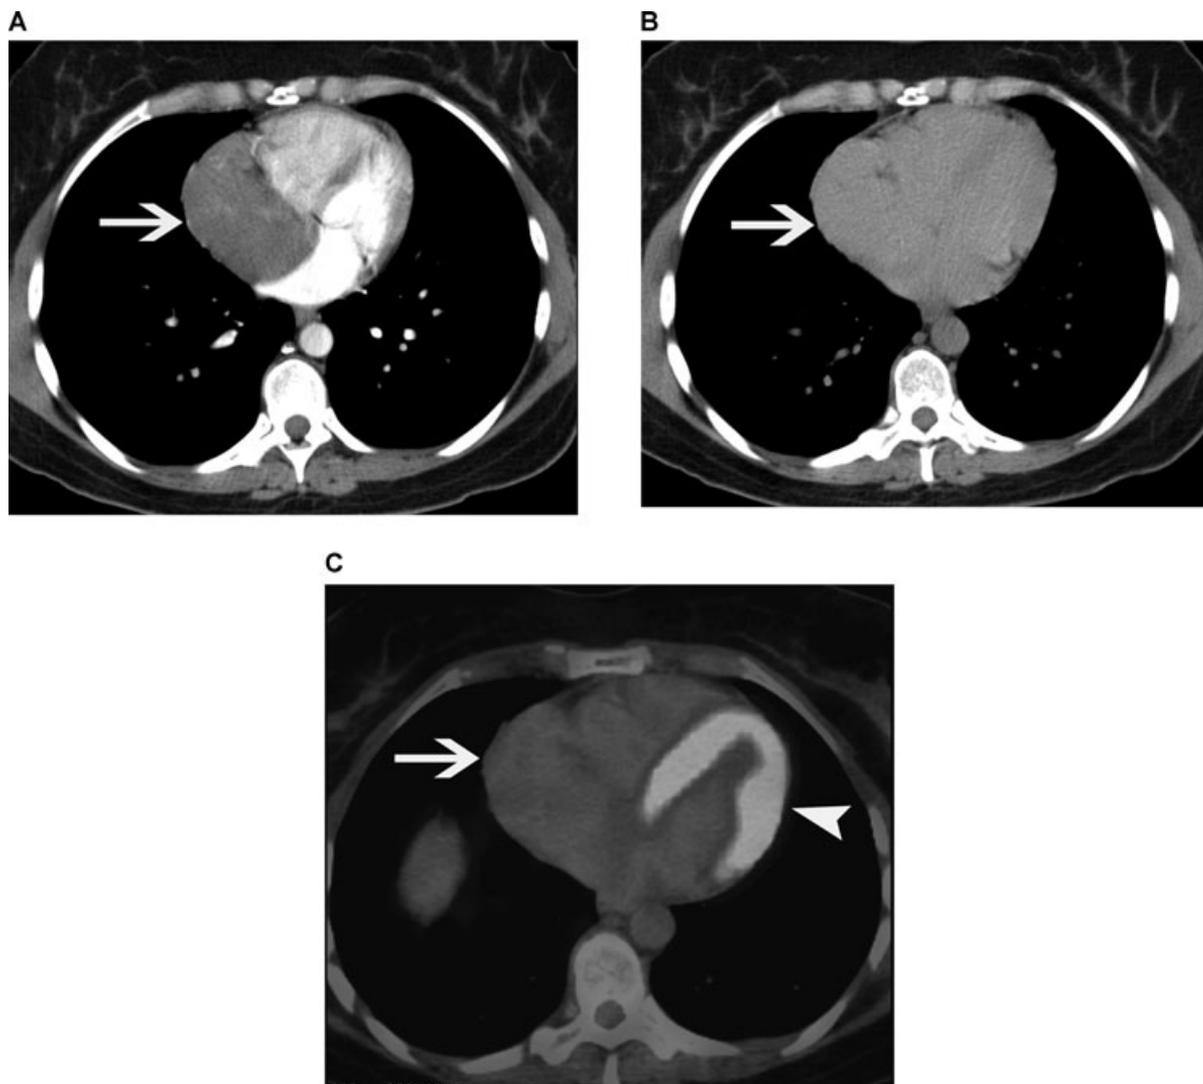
Computed tomography (CT) and FDG PET/CT images. A. CT image obtained immediately after administration of intravenous contrast shows large right atrial mass (arrow). B. Delayed CT image obtained about 5 minutes later shows that the tumor (arrow) has enhanced to the same degree as the blood pool indicating that it is highly vascular. This pattern of enhancement (no central enhancement immediately after intravenous contrast administration with delayed enhancement isodense to the blood pool) is typical of hemangiomas in the liver also. C. ^{18}F -fluorodeoxyglucose (FDG) PET/CT fusion image shows no hypermetabolic activity in the tumor (arrow) consistent with a benign lesion. Note normal activity in myocardium of left ventricle (arrowhead).
